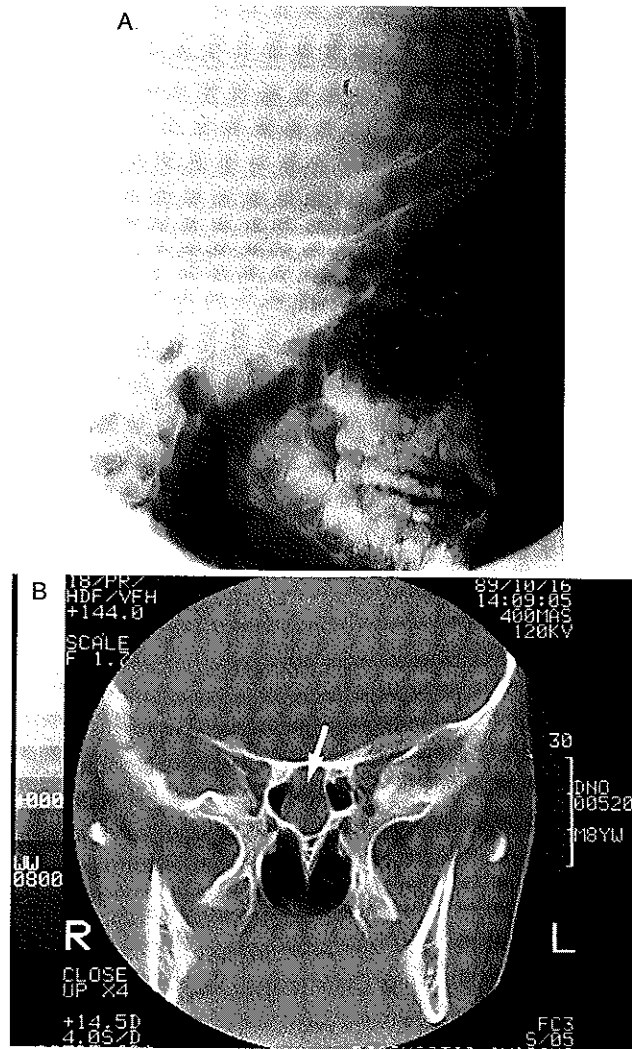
A, plain x-ray film of the sinuses (lateral view) showing no apparent sphenoid disease. B, coronal CT of the sinuses of the same patient in A showing a large right sphenoid mucous retention cyst (arrow).
